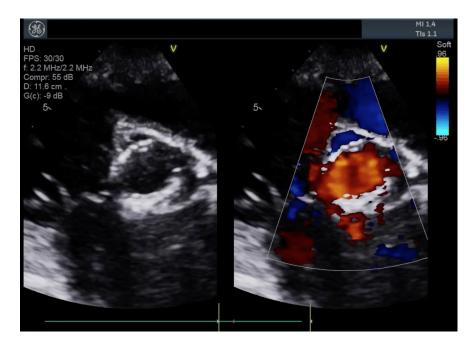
Transthoracic Echocardiogram in parasternal short axis view post balloon valvuloplasty of the prosthetic aortic valve demonstrating the resolution of valvular regurgitation.
